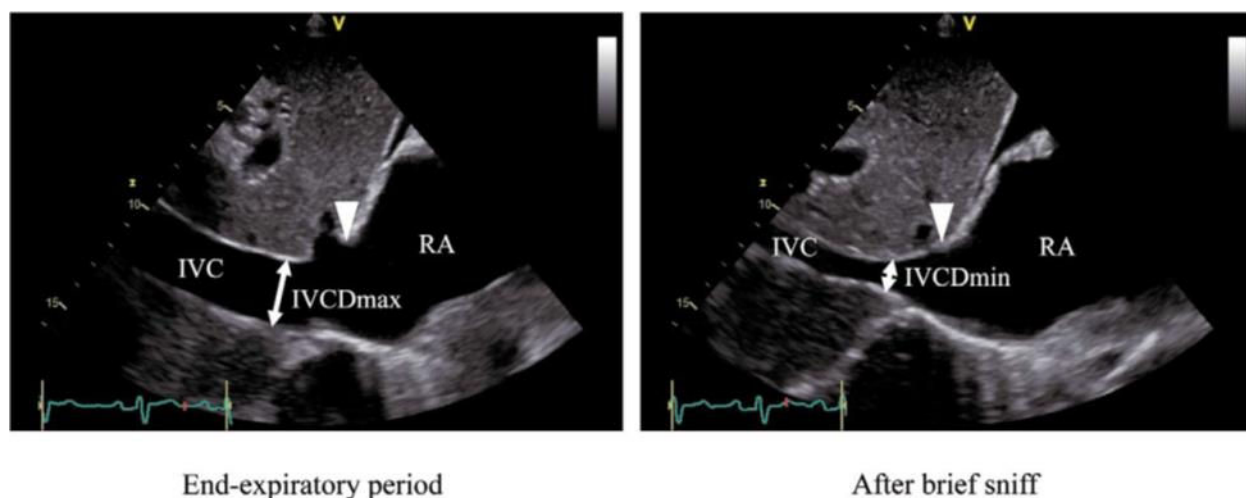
Example of IVC ultrasound in the subcostal long axis view: Arrow head indicates the IVC-RA junction. IVC: Inferior Vena Cava; RA: right atrium [5].
